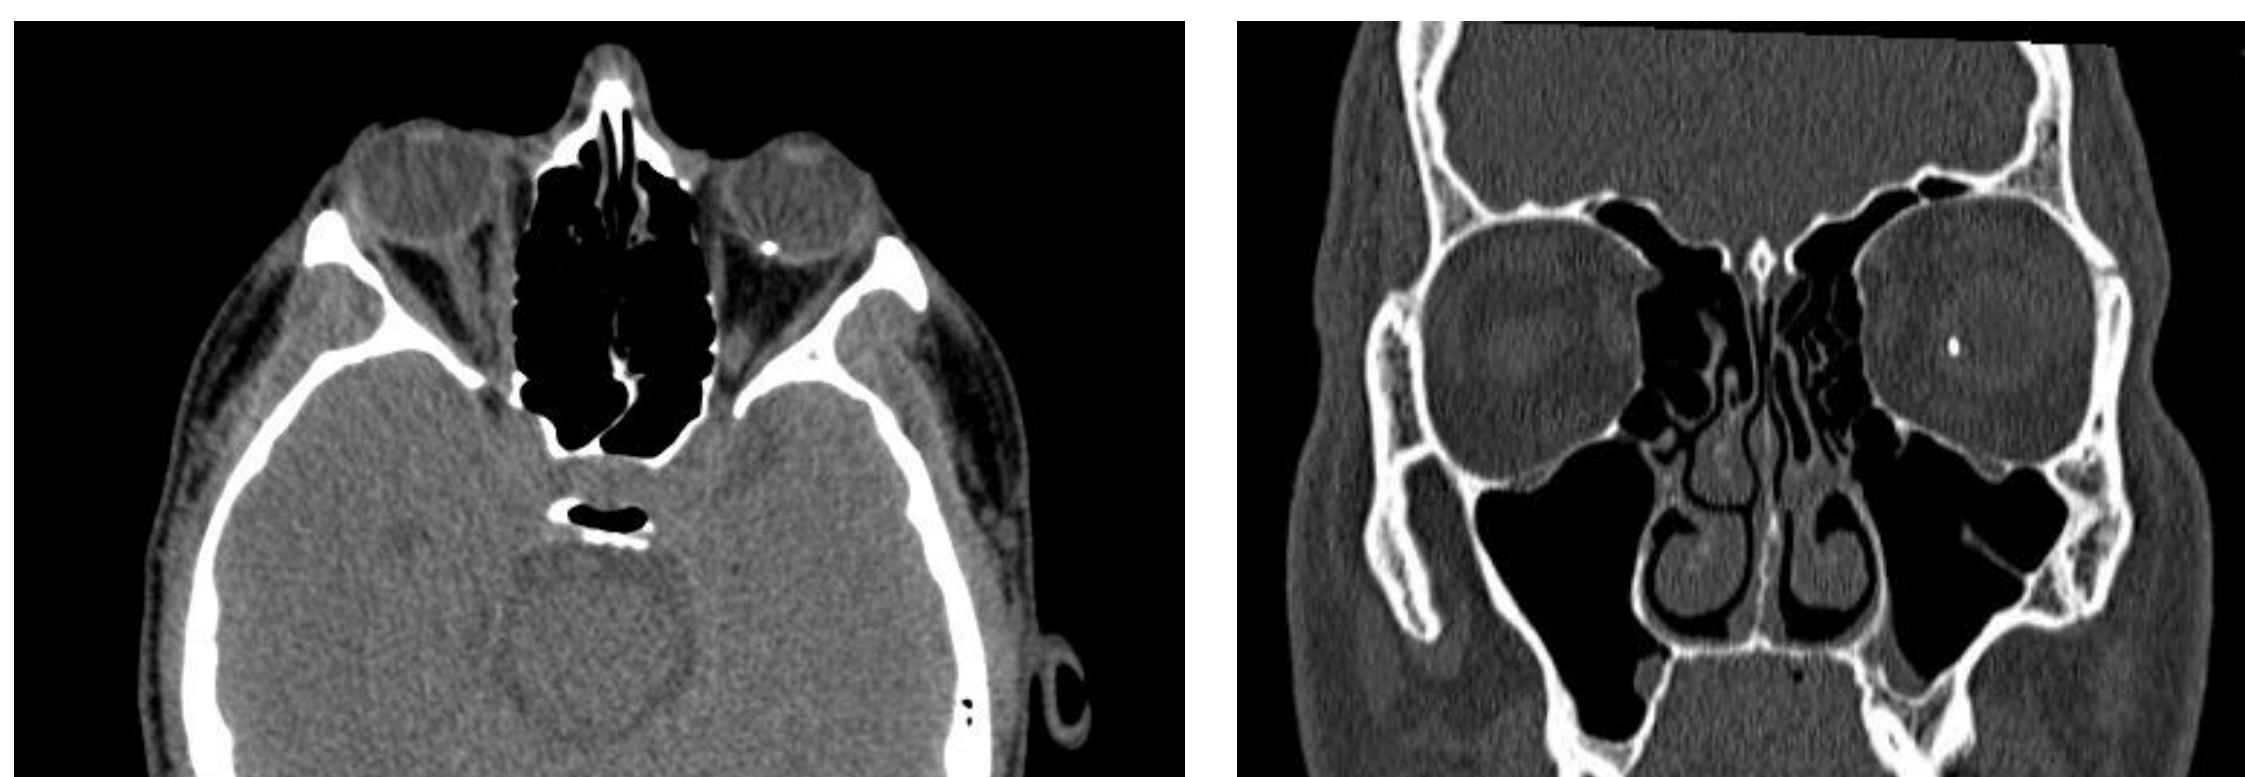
Axial (left) and coronal (right) sections of computed tomography of the orbits show an intraocular foreign body in OS. Note that the IOFB is localized near the optic disc.
